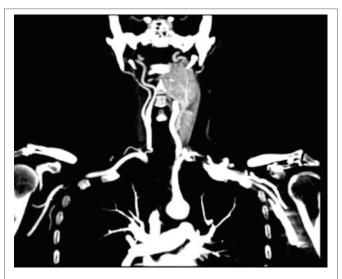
CT angiography of a VPG.
